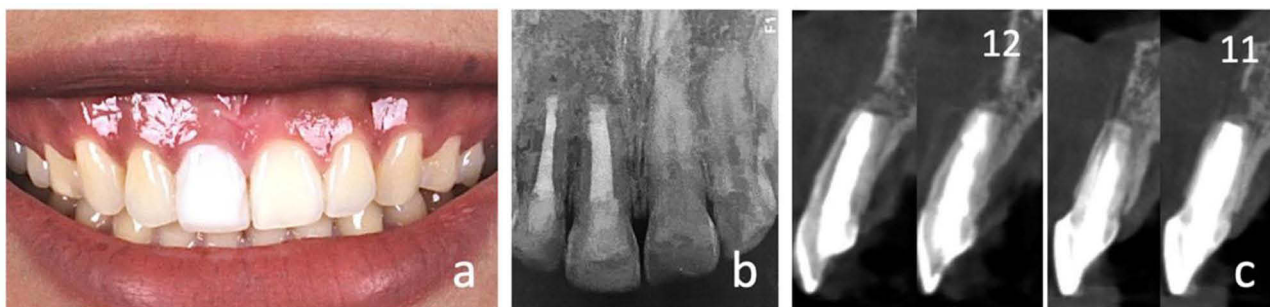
(a) One-year clinical evaluation. (b) Periapical x-ray photo shows healing of periapical lesions (c) Sagittal slices CBCT assessment show bone deposition surrounding the root tips of #12, 11.
